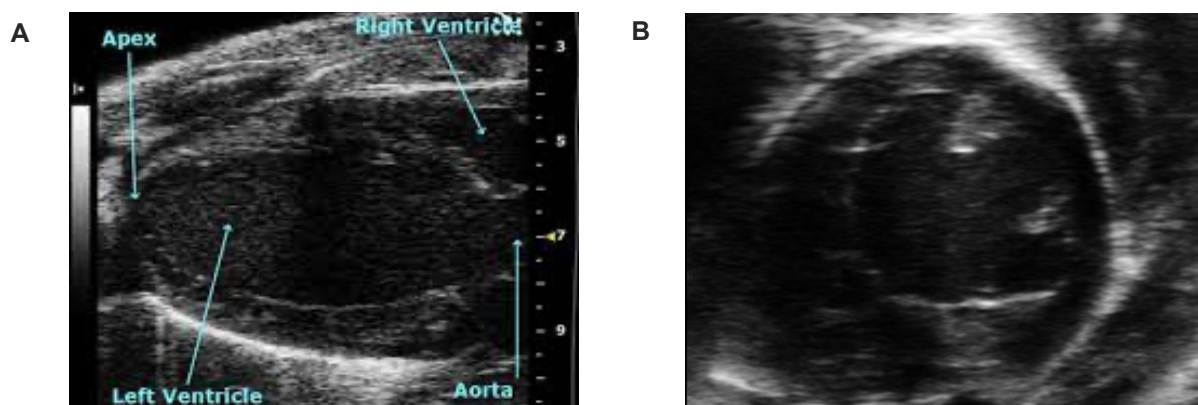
Echocardiography analysis.
